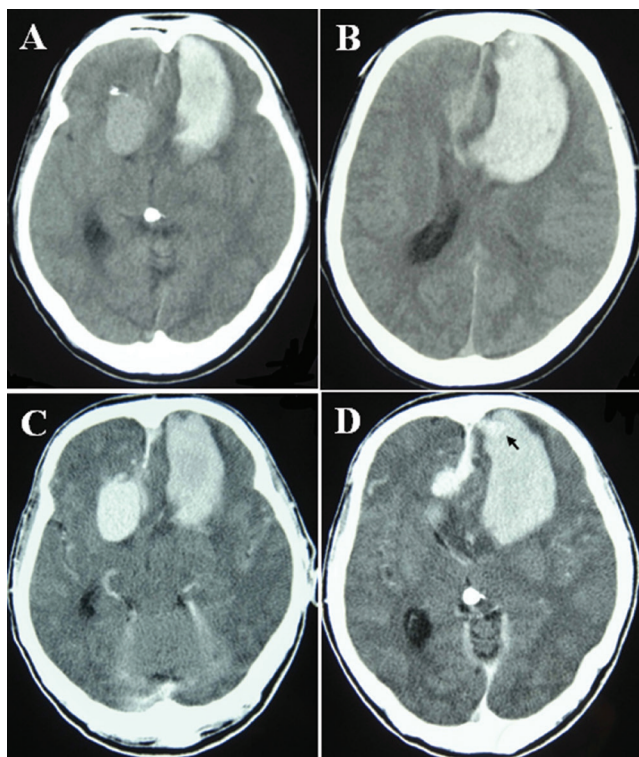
A, B: Pre-contrast computed tomography (CT) scan showed the intracerebral hematoma in the left frontal lobe and the isodensity round mass in the right frontal lobe. C, D: Post-contrast CT scan revealed the left midline small enhanced lesion adjacent to the hematoma (arrow) and the right isodensity round mass was homogeneously enhanced.
